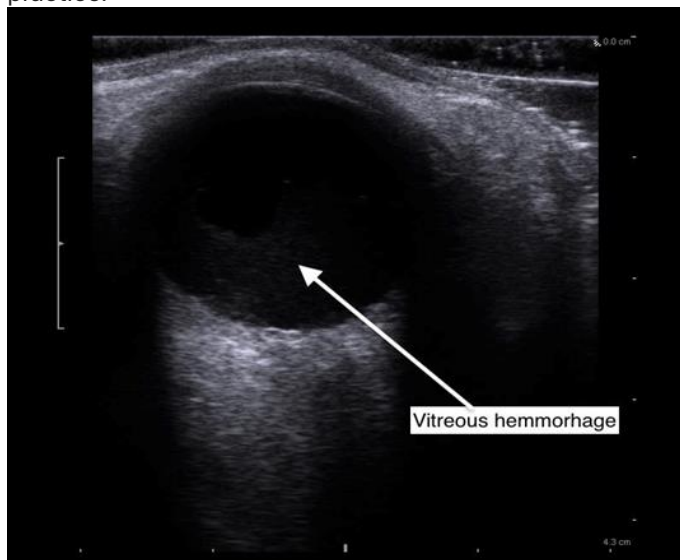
Ultrasound image showing vitreous haemorrhage.
